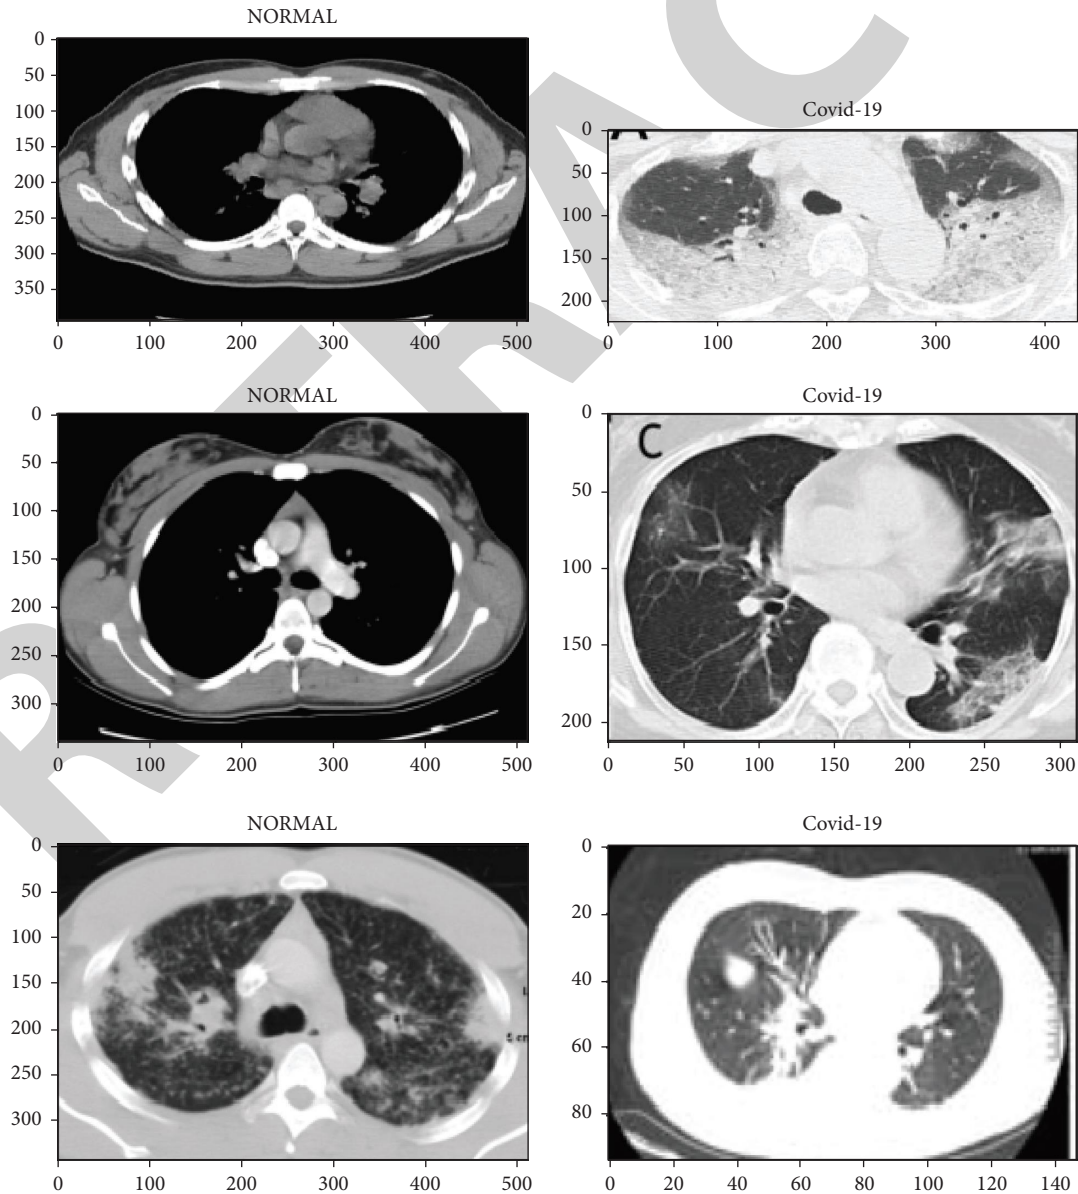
CT lung COVID-19 image cases that include normal and COVID-19 samples.
